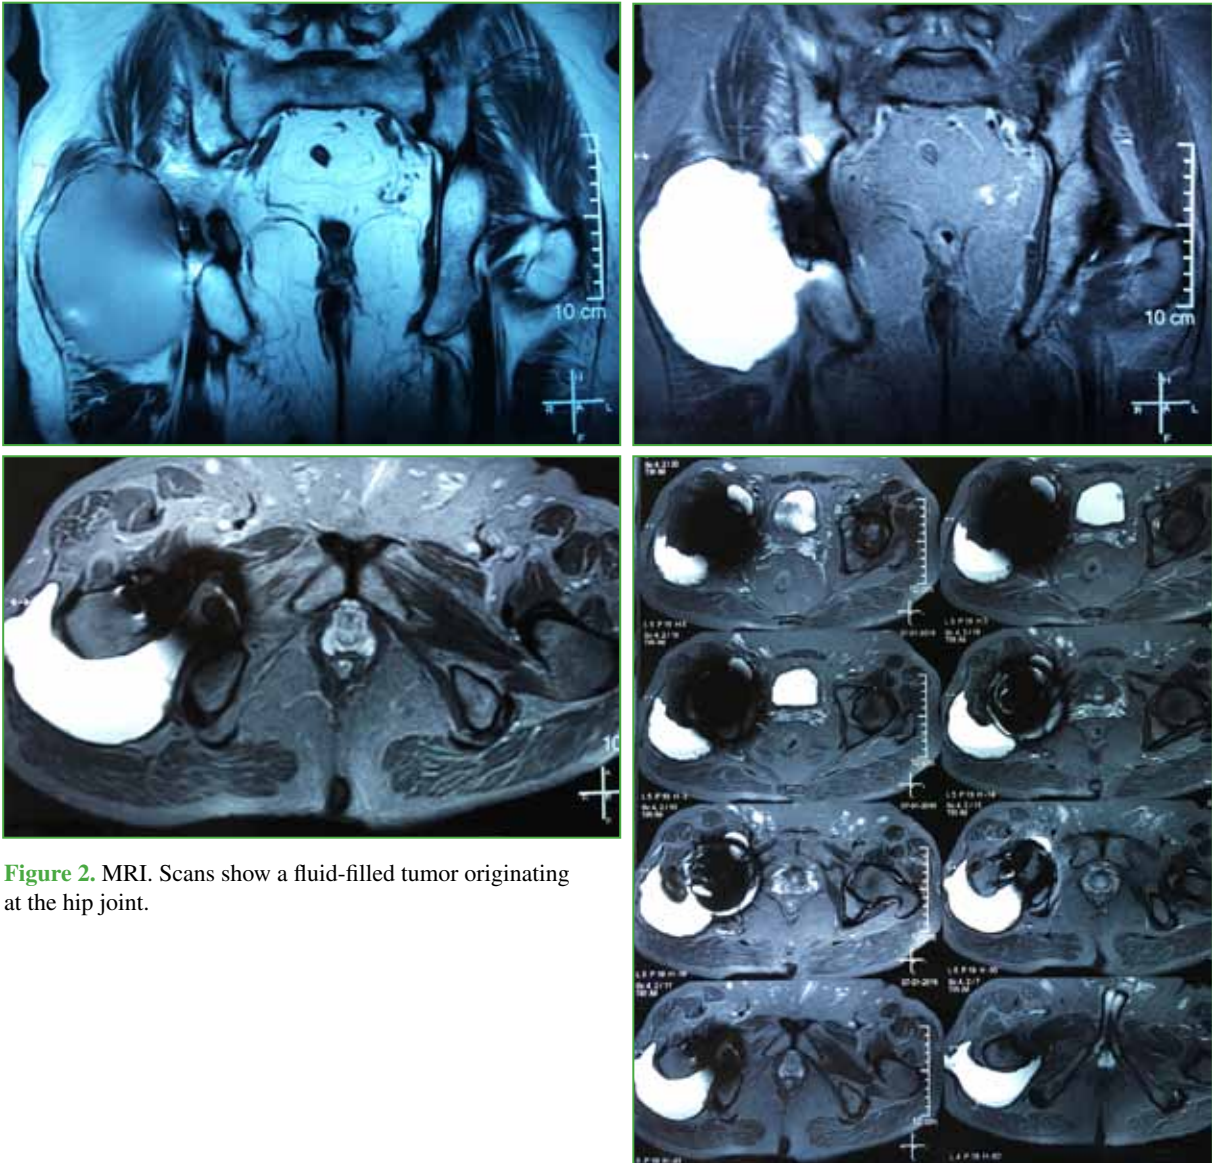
MRI. Scans show a fluid-filled tumor originating at the hip joint.
